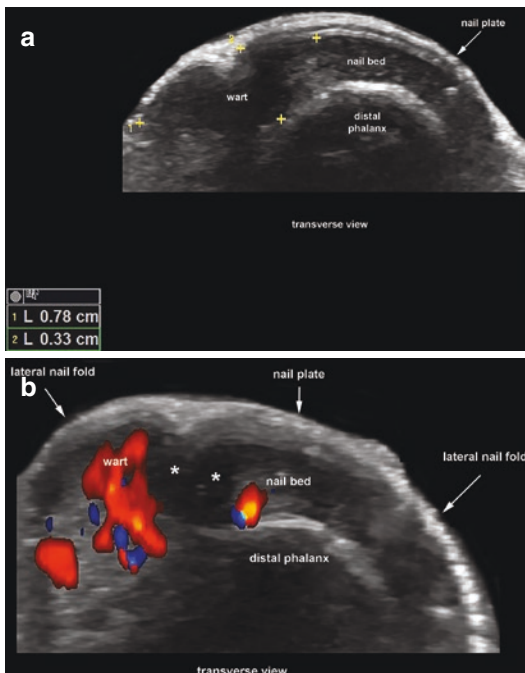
(a, b) Subungual and periungual wart. (a) Grayscale and (b) color Doppler ultrasound (transverse view; left ring finger) of the same case of Fig. 18.15 demonstrate hypoechoic fusiform thickening of the nail bed and periungual dermis of the lateral nail fold (radial border). Notice the subungual and dermal hypervascularity in b
